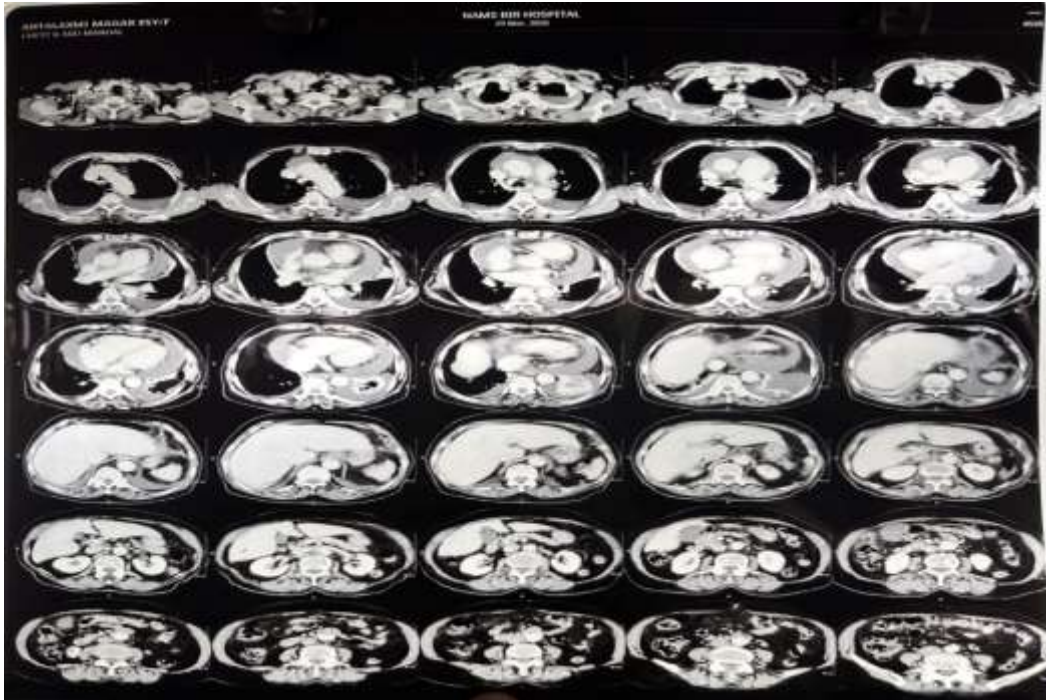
Contrast-enhanced computed tomography (CECT) scan of the chest and abdomen demonstrating a bilateral pleural effusion with adjacent passive lung atelectasis, severe cardiomegaly, and a gross pericardial effusion.
